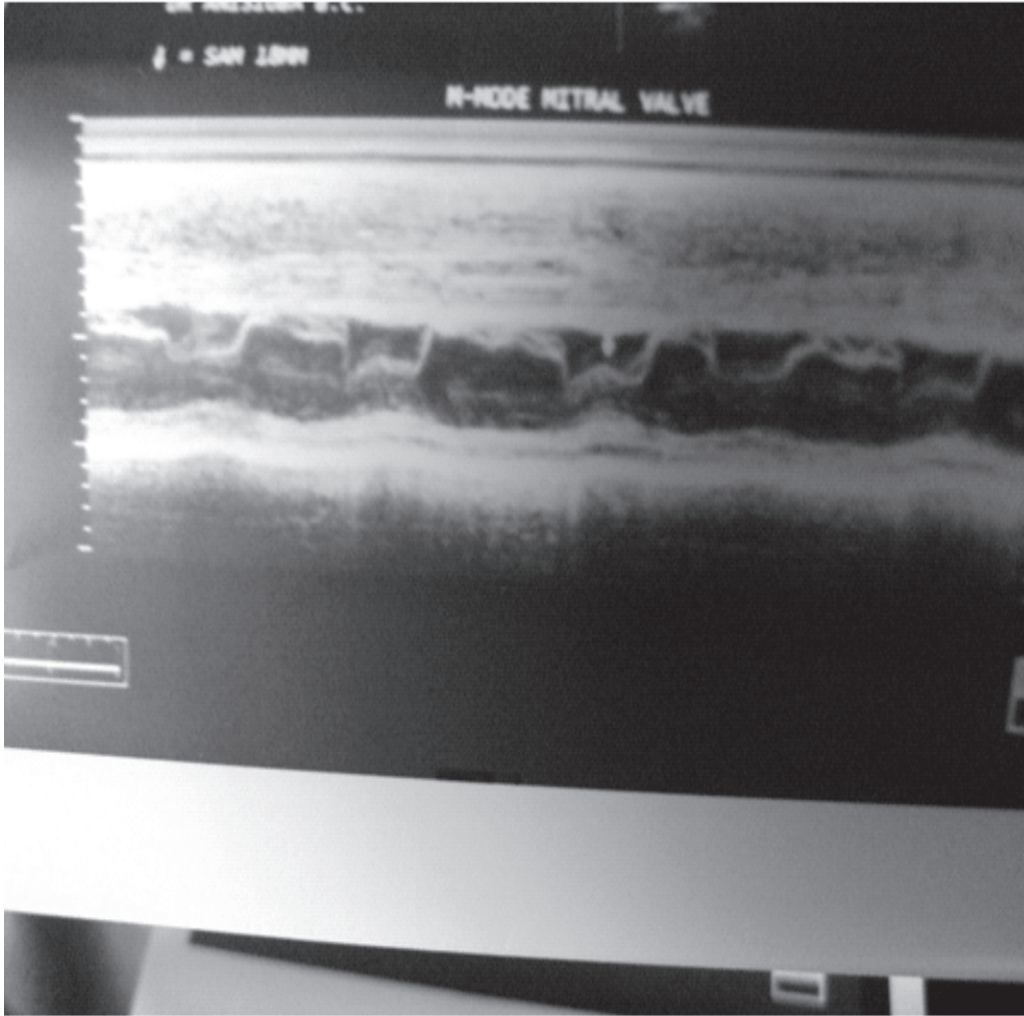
M-mode echocardiography of the patient across the mitral valve showing Systolic Anterior Motion (SAM) of the anterior mitral valve leaflet. Arrows shows the leaflet making contact.
